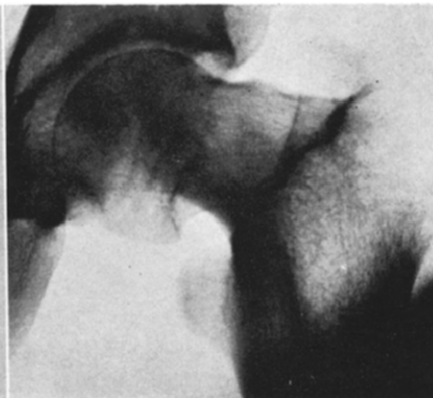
Case XII. Roentgenogram one-half year after drilling, November 10(?), 1932; firm fusion; primary focus still outlined in head.
